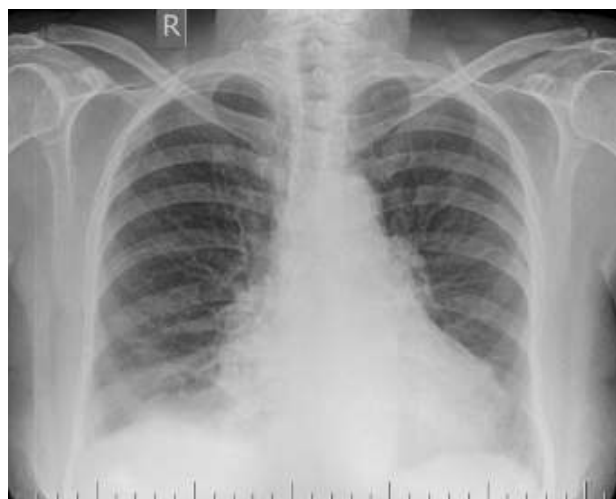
Chest radiograph – posteroanterior view at presentation
